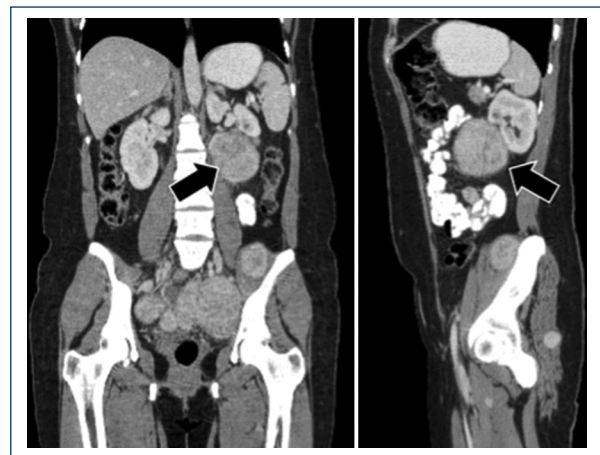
Computed tomography: heterogeneous mass with well-defined borders that displaces the left kidney.
